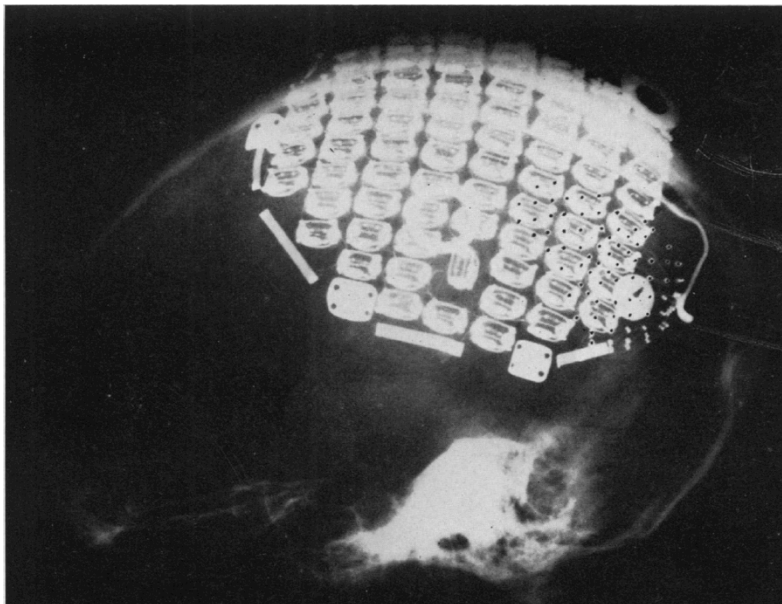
Skull x-ray of the patient implanted with the cortical prosthesis by Brindley et al. Eighty intracranial platinum electrodes were implanted over the calcarine and neighbouring cortex, which were in turn connected to 80 corresponding extracranial radio receivers, embedded under the pericranium. (Image from (Brindley and Lewin, 1968))
